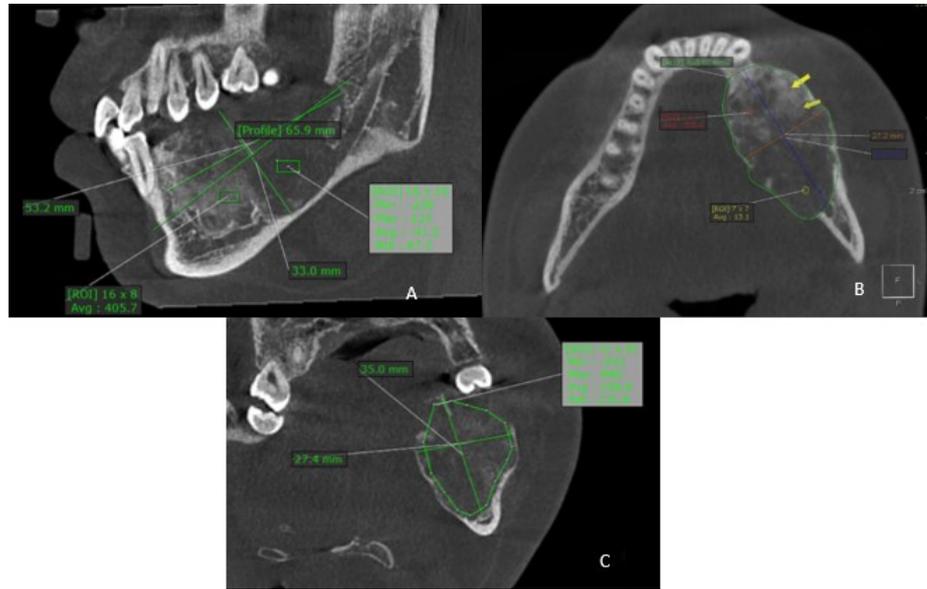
CBCT radiographs, (A) Sagittal section shows a mixed radiopaque radiolucent lesion in the mandibular body area of teeth 33-38, (B) Axial view shows buccal and lingual expansion of the lesion, (C) Coronal section showing a lesion expanding supero-inferiorly involving the mandibular canal
